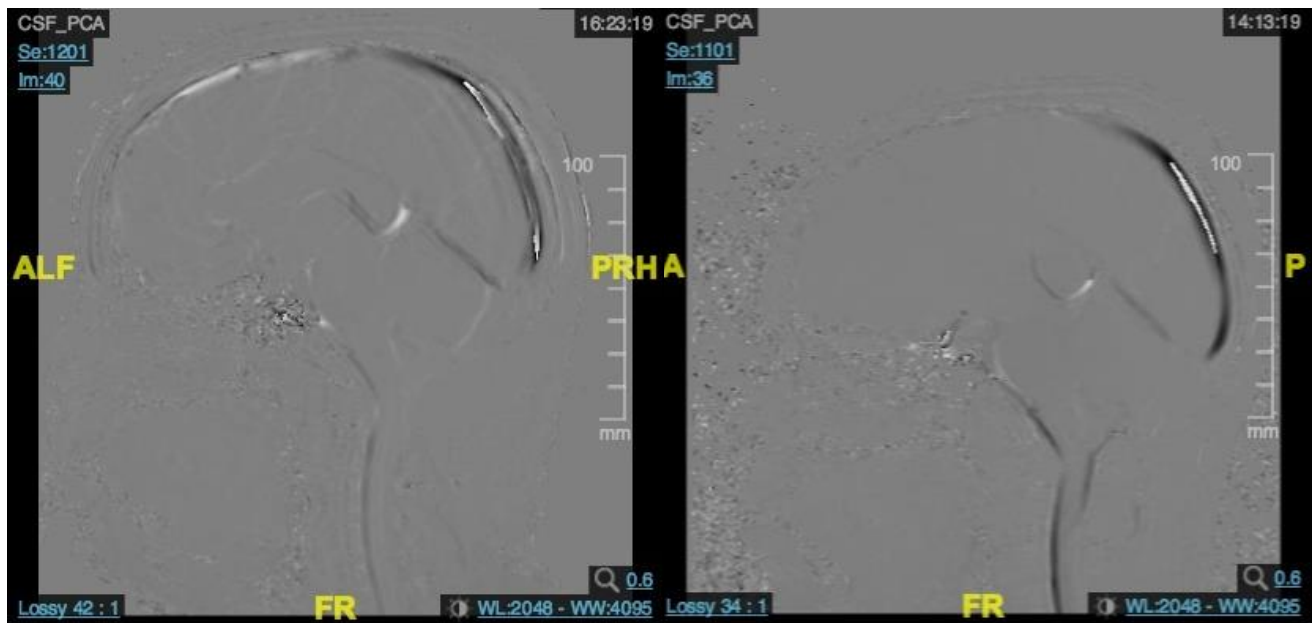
MRI CINE showed pre and postoperative CSF flow at posterior foramen magnum (right).
